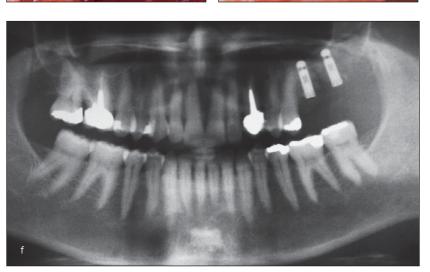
Panoramic radiograph showing 2 ulna bone-implant grafts in the sinus.
